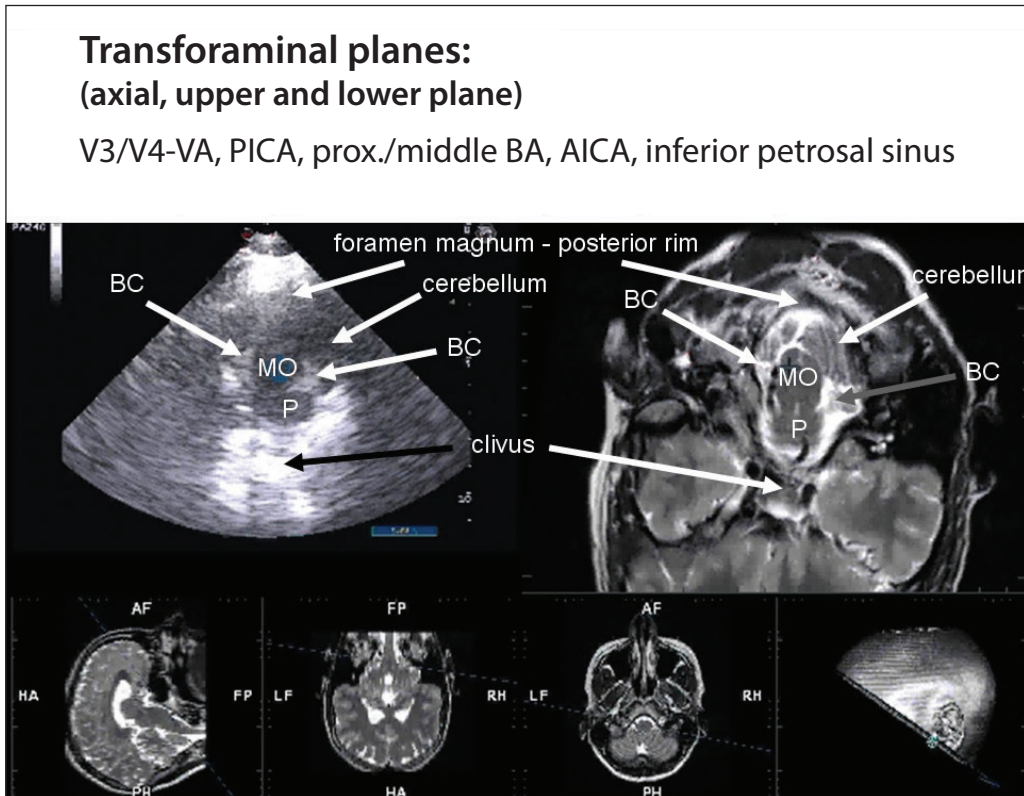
Transforaminal plane: B-mode. Vessel segments which can be identified by transcranial color-coded sonography (TCCS) via the transforaminal approach. Example of UFI (ultrasound fusion imaging) B-mode imaging of the upper transforaminal plane, matched with a T2-weighted MRI dataset of a patient without pathological findings. Note the clear delineation of the medulla oblongata (MO), the partial imaging of the lower pons (P) and the hyperechogenic appearance of the basal cisterns, differing from the echogenicity of the bone rim of the foramen magnum.
